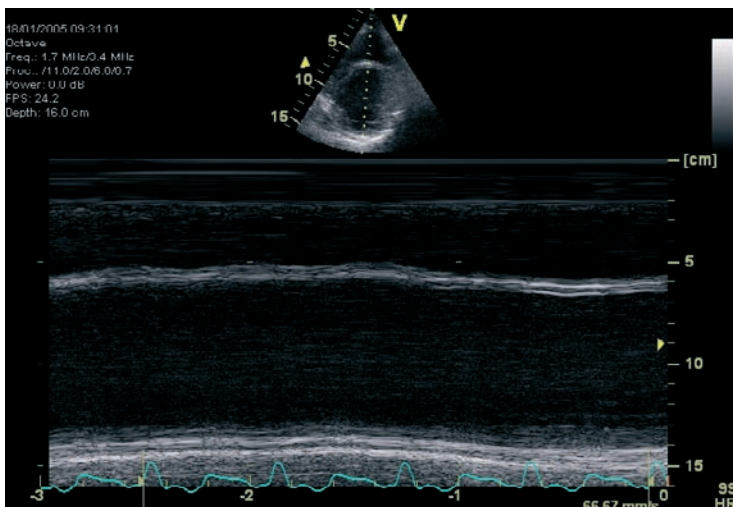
Example of a patient in whom assessment of left ventricular dyssynchrony using M-mode echocardiography was not feasible due to akinesia of both the inter-ventricular septum and the posterior wall.
